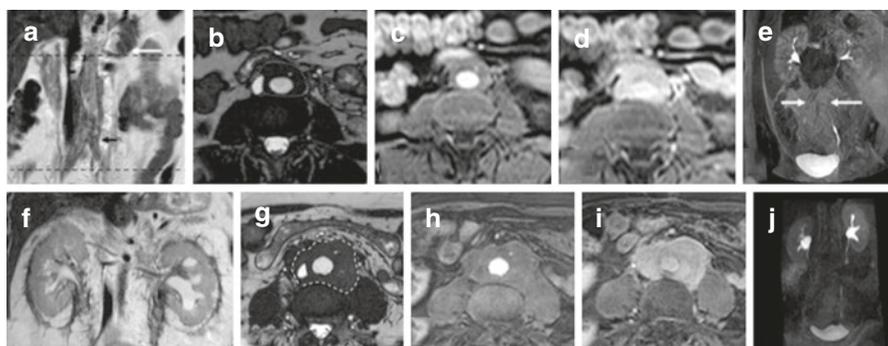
(upper row): Characteristics of benign RPF. Abdominal MRI depicts extension of periaortic disease (image a, dotted lines; image b, dotted white contour) between the renal arteries (white arrow) and the aortic bifurcation (black arrow) on T2-w spin-echo coronal (a) and axial T2-w BFFE (b) images. The periaortic disease prevails at the anterior part of the aorta on axial images (b–d); intense but progressive enhancement is seen on gradient-echo T1-w fat-saturated dynamic contrast-enhanced series (c and d at early and late phases of injection, respectively), together with medial ureteral attraction (image e; white arrows) on late urogram. (lower row): Characteristics of malignant RPF in two different patients. (f) in a case of Erdheim–Chester Disease (ECD), perirenal fibrosis is seen on T2-w coronal view. (g–j) biopsy proven non-Hodgkin lymphoma with extensive fibrosis from below the renal arteries to the iliac bifurcation, involving the retroperitoneal space in front and behind aorta (g; white dotted contour) on axial T2-w (g), T1-w dynamic contrast enhanced at early (h) and late (i) phases of injection, without attraction of ureters on the MR-urogram (j), and, in this case, no upper tract enlargement. Larger extension behind aorta is also visible
